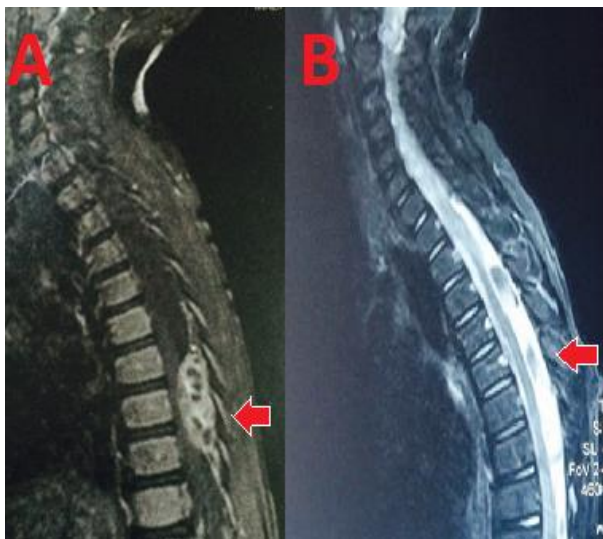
Patient 3 spine MRI. A: preoperative T1 injected sequence; B: postoperative T2 WI.
